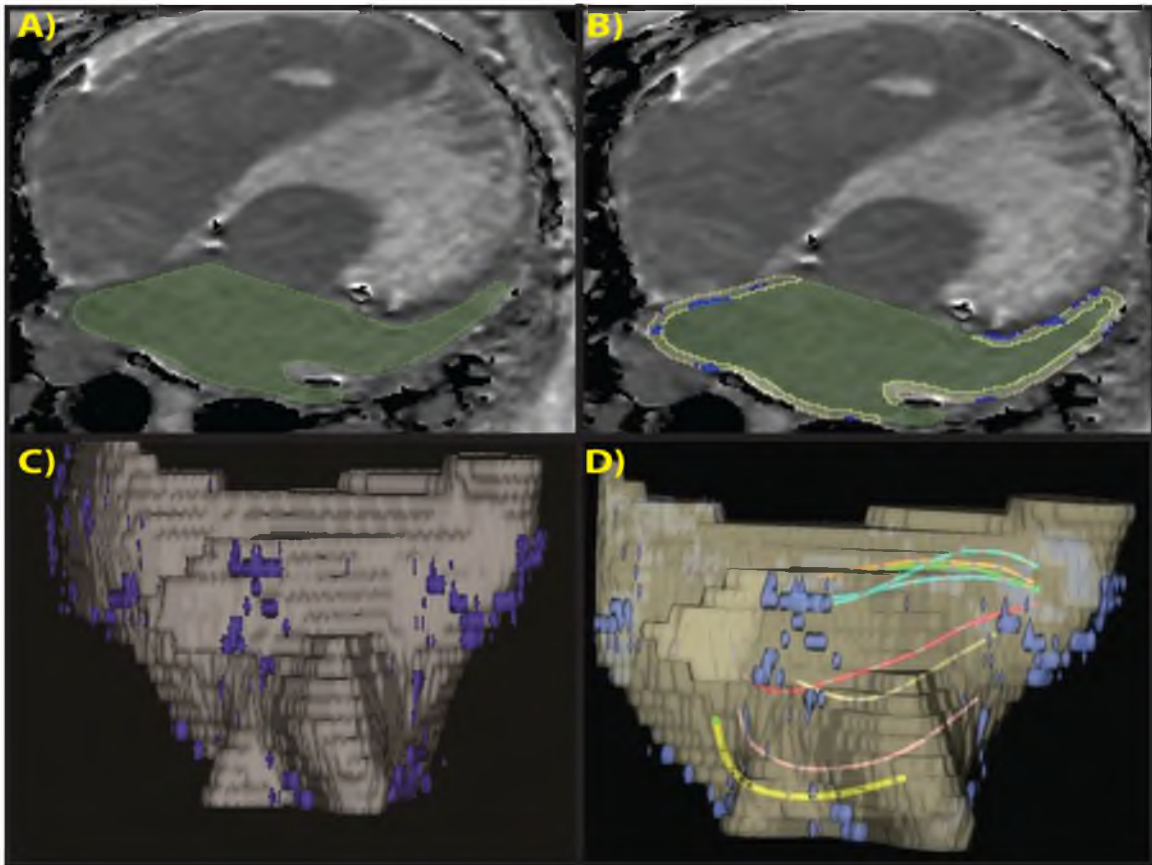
Determining regions of fibrosis using T1-Mapping MRI. A) One axial slice from a series of 52 slices of the T1 Map. LA blood pool segmentation is in green. B) LA wall segmentation, shown in grey, and the lowest 10% T1 values in blue from the T1 map slice in A). C) 3D segmentation of LA wall and lowest 10% T1 values. This segmentation is imported into the EnSite mapping system for merge with the geometric shell created from a mapping catheter. D) Basket catheter shown in segmentation merged with EnSite created EAM of the LA. Grey is the LA wall and the blue are the regions of lowest 10% of T1 value.
